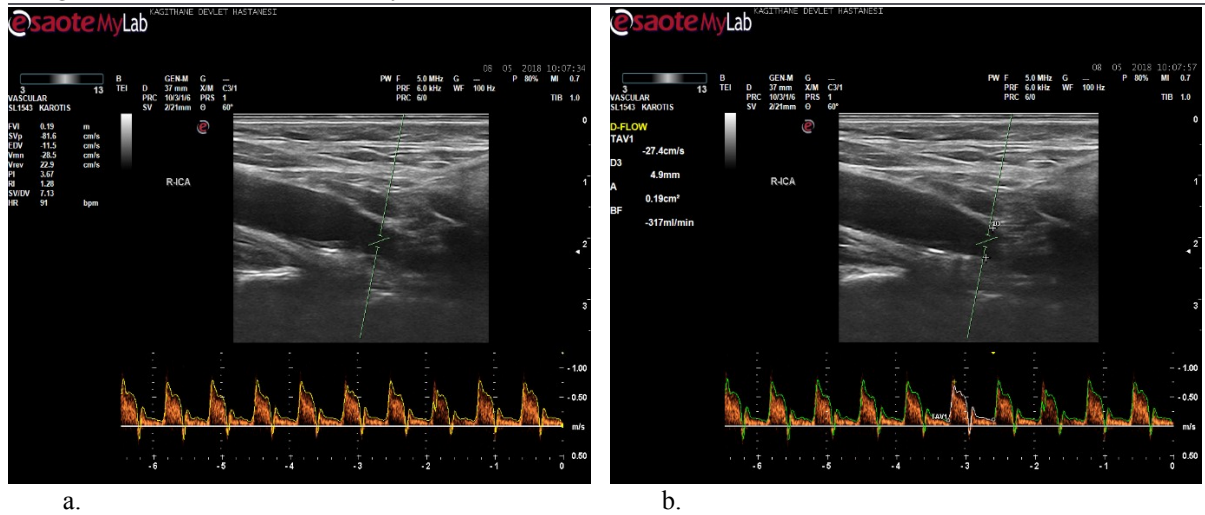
Doppler ultrasonography measurement of the vessel diameter, peak-systolic velocity (PSV), end-diastolic velocity (EDV), resistive index (RI), pulsatility index (PI) (a), and blood flow in the internal carotid artery (ICA) (b).
